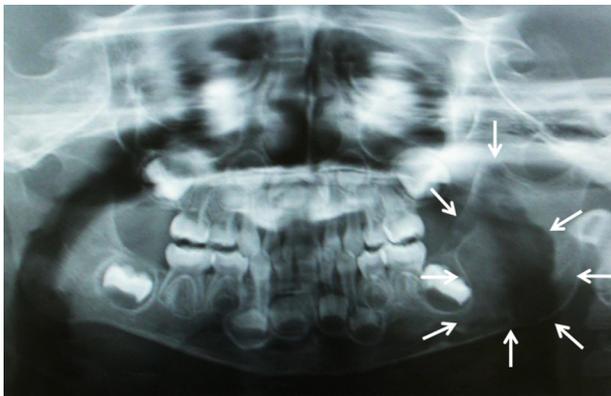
Panoramic radiograph showing a well-circumscribed radiolucent lesion from the left branch to the body of the mandible.
